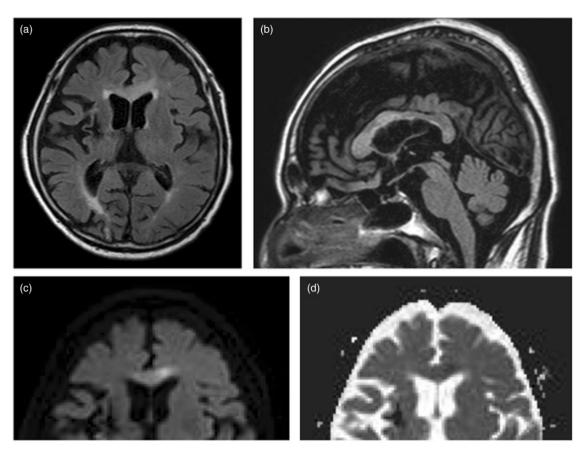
Images taken on the 12th hospital day after admission. (a, b) FLAIR imaging of axial and sagittal section. Hyperintensity in the frontal white matter is reduced. Hyperintensity of the corpus callosum is still apparent. Cavity formation at this site is not apparent at this time. (c) DWI hyperintensity of the corpus callosum is apparent. (d) ADC mapping. Hypoto isointensity in the corpus callosum is found.
